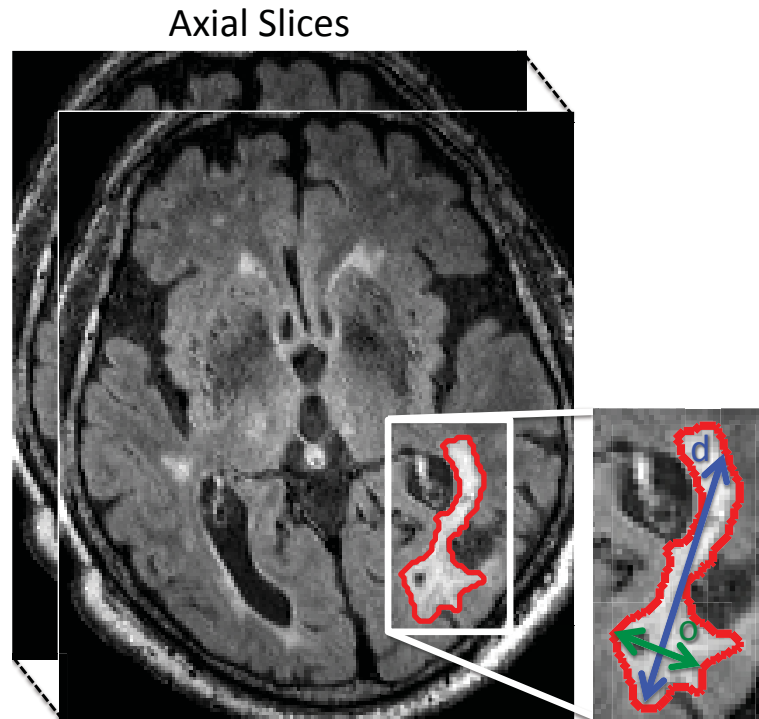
Diameter-based measurements on a single-axial section used for the evaluation of tumor size on serial MR image studies.  $d$  is the maximum tumor diameter among all the axial slices of a lesion and  $o$  is the maximum diameter orthogonal to  $d$  within the same axial slice. The RECIST criterion uses  $d$  to determine the progressive state of the lesion (1D-based) while the Macdonald and RANO criteria use the product  $d * o$  (2D-based).
